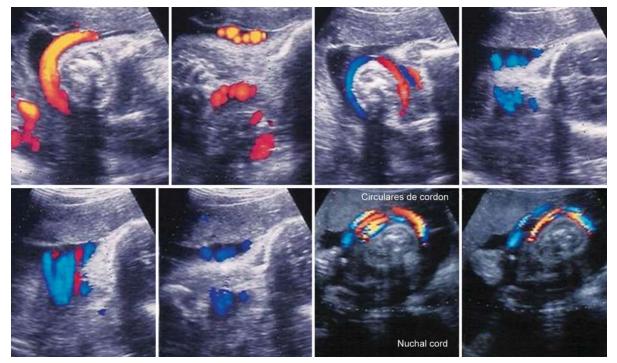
Color Doppler showing a cord loop around the neck. Although this image is a typical finding with 2D, it is not always seen clearly. Sometimes it is difficult to be suspected if this technology (Doppler) is not used. The below right picture shows two loops around the neck
